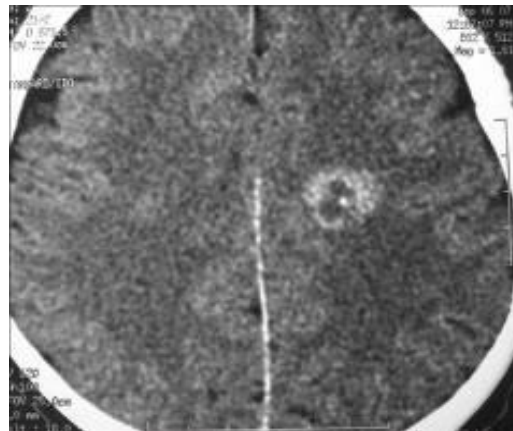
Contrast-enhanced CT Brain showing Solitary Tuberculoma in the Left Parietal lobe
